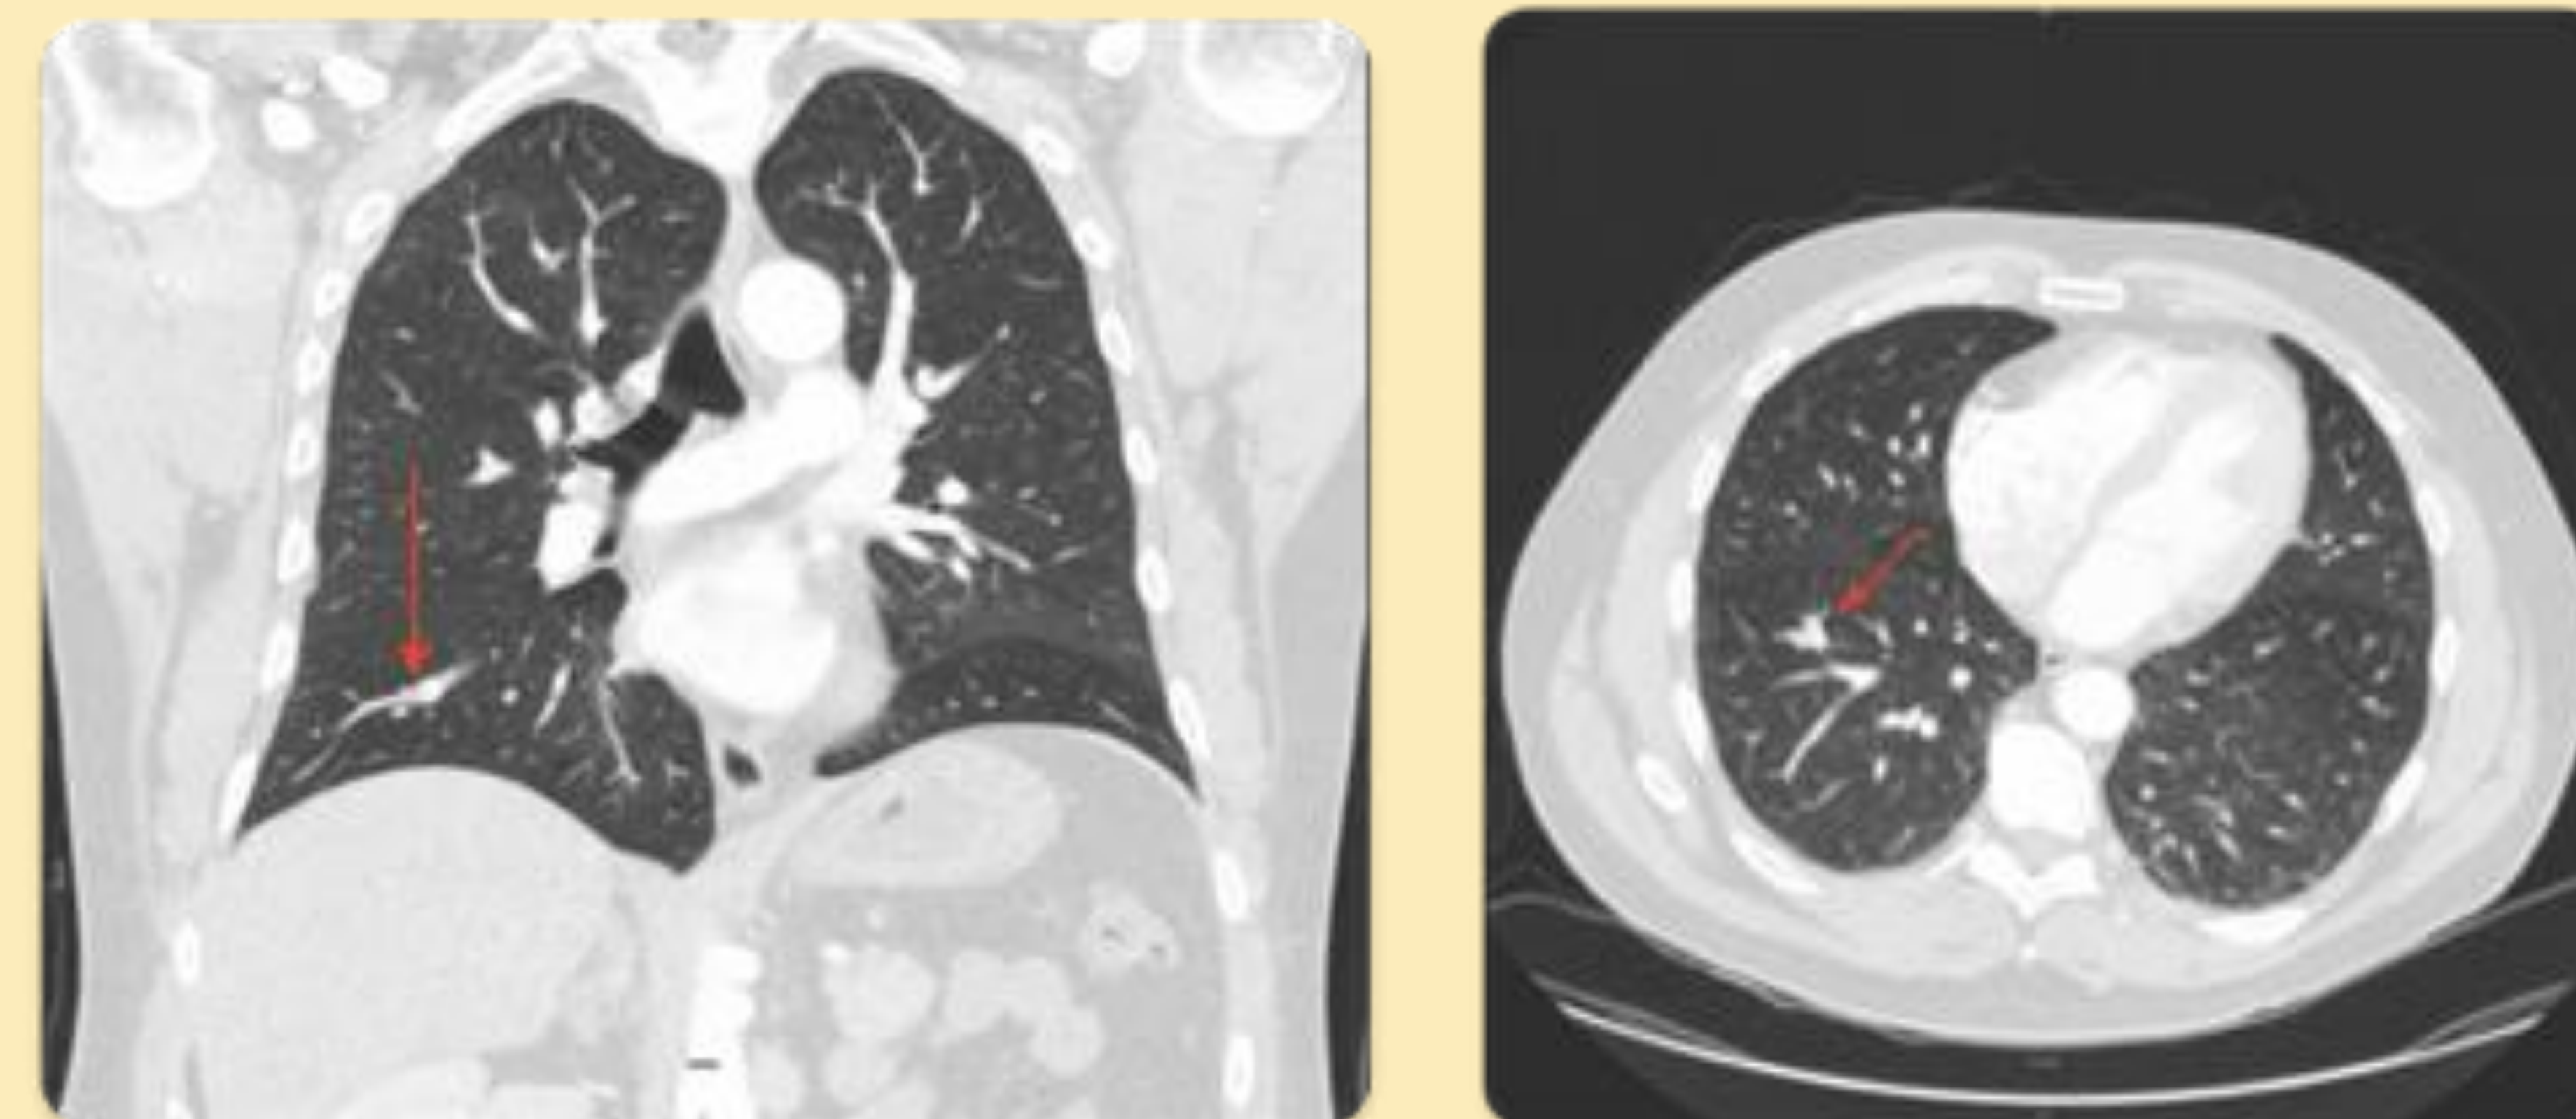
Computed tomography angiography of the chest with acute thromboembolism in right sub-segmental branch (left - coronal, right - axial).
